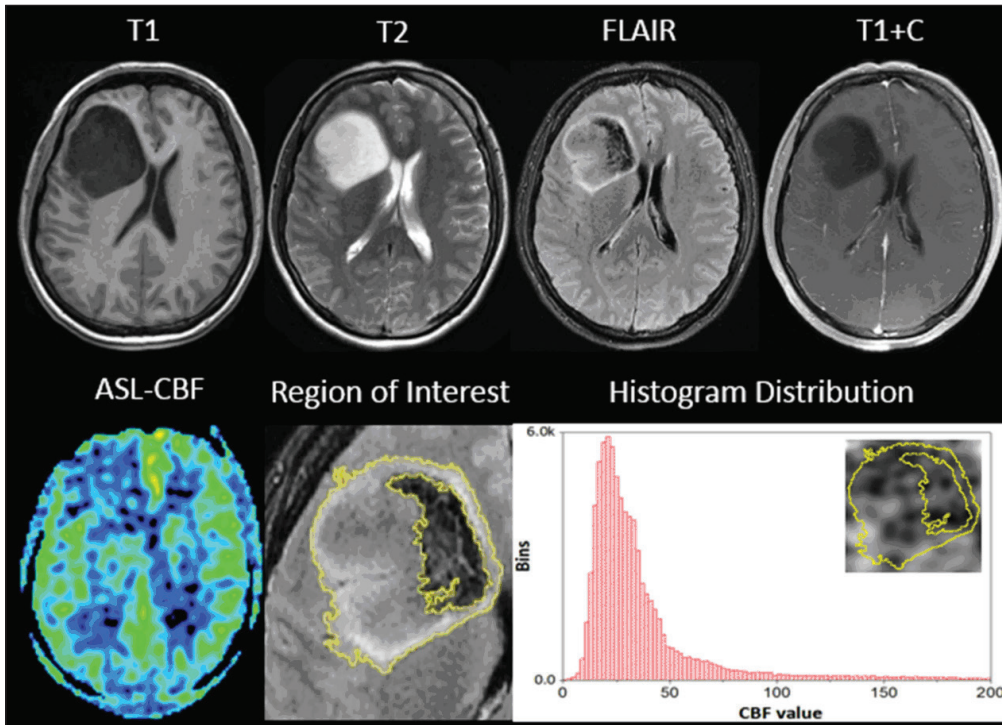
Representative case of isocitrate dehydrogenase mutant and lower-grade gliomas. A 28-year-old woman was diagnosed with diffuse astrocytoma (grade II), The right frontal lesion with long T2 and T1 showed no evident enhancement with a sharply defined boundary. A representative region of interest was overlaid on fluid-attenuated inversion recovery MRI. Compared with the contralateral normal brain, the lesion had a relatively low perfusion with a laterally distributed perfusion histogram.
